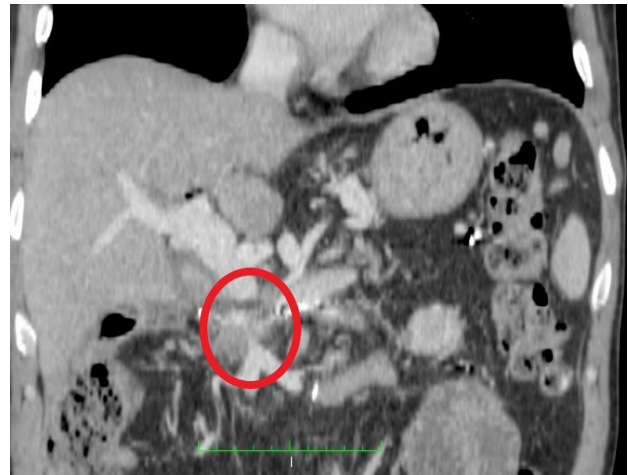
CT angiography 13th February 2018 distal part occlusion of v. mesenterica sup.
